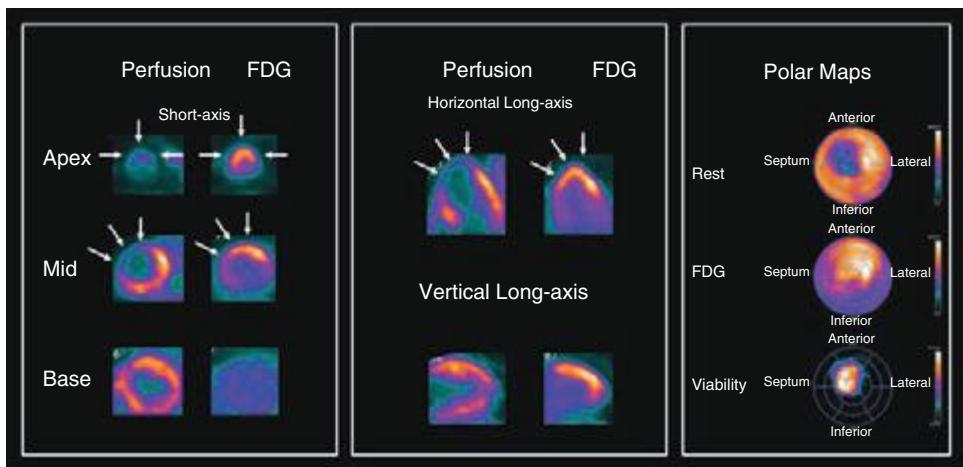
11 Rest myocardial perfusion and metabolism positron emission tomography (PET) scan obtained with ^{13}N -ammonia (perfusion) and ^{18}F -fluorodeoxyglucose (FDG; glucose metabolism) in a 48-year-old male with a prior myocardial infarction. The rest perfusion images show a large defect involving the apex, apical segments, and mid-anteroseptal and anterior segments (arrowheads), which has associated increase in glucose uptake (perfusion-metabolic mismatch), reflecting viable but hibernating myocardium throughout the left anterior descending coronary territory.
